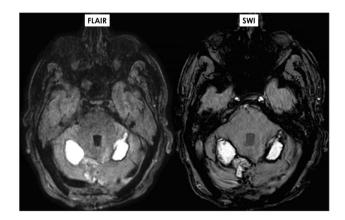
Brain MRI at 10 days from the hospital admission, showing in Fluid Attenuated Inversion Recovery (FLAIR) axial section and in the corresponding Susceptibility Weighted Imaging (SWI) section reconstructed in Minimum Intensity Projection/Multiplanar Reconstruction (MinIP/MPR) the hyperintense hemorrhage in the deep portion of both cerebellar hemispheres
